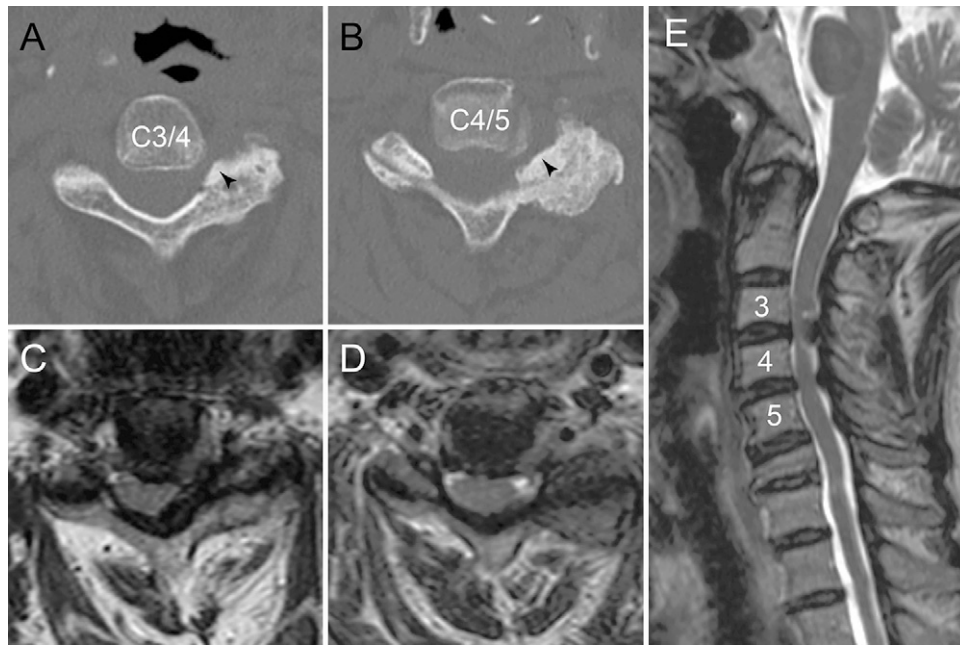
Preoperative cervical CT shows foraminal stenosis at the C3–4 (A) and C4–5 levels (B) due to excessive osteophytes (arrowheads). The spinal nerve roots and spinal cord are compressed in the corresponding axial (C and D) and sagittal (E) MRI.
